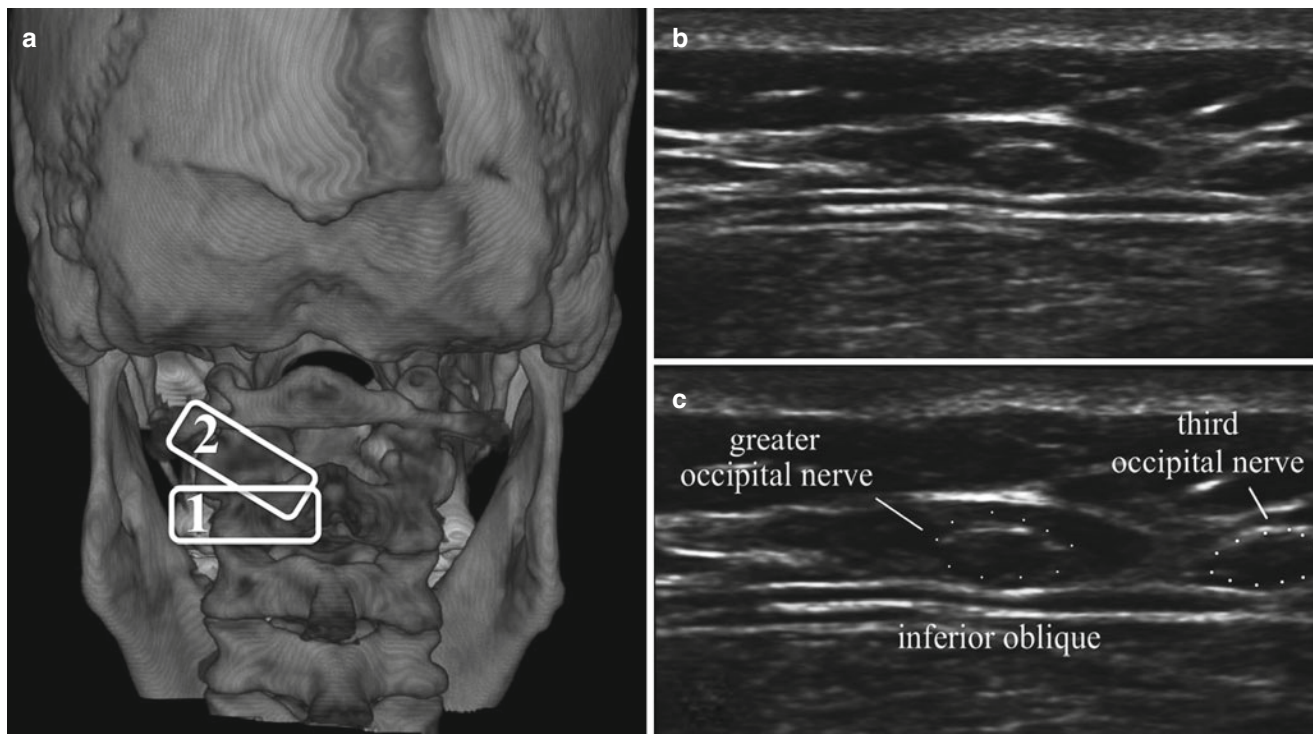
US imaging of the third occipital nerve. (a) Location of ultrasound transducer: 1 = the initial probe placement; 2 = the final probe placement. (b) US image of the proximal third occipital nerve. (c)
